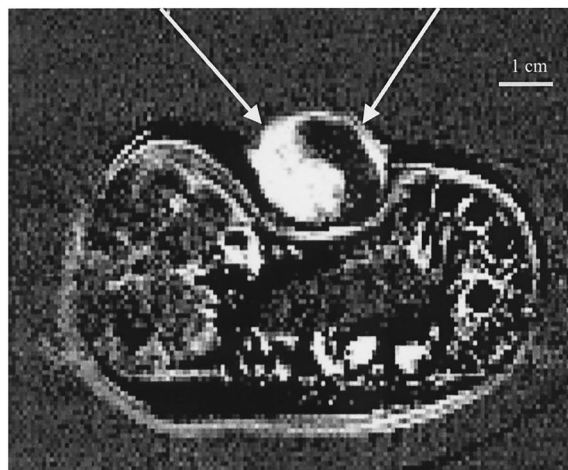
(a) MRI Gd-DTPA enhancement map with MB peak information located above each region. (b) MB concentration during short times for quickly enhanced (solid curve) and slowly enhanced (dotted curve) regions of the tumor.
